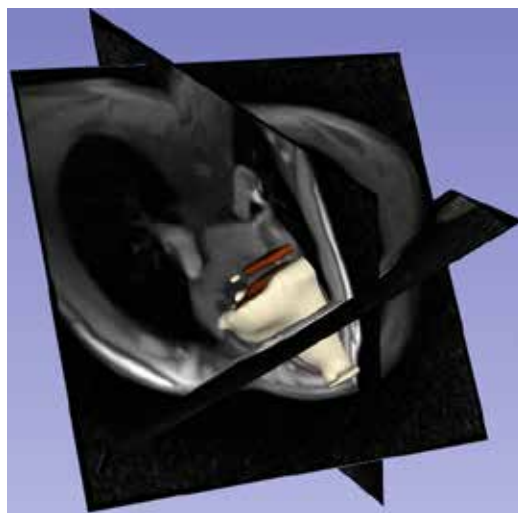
This image shows a univentricular heart with a hypoplastic right heart. The heart was scanned with cardiac real-time MRI in short axis direction (transverse to the longitudinal axis) during spontaneous breathing. The cardiac short axis slices were segmented with artificial intelligence sorted automatically for their cardiac and respiratory phase to create a 3D stack representing end-diastolic and end-expiratory phase. The cross-sections in the image are shown in figure 1b.
